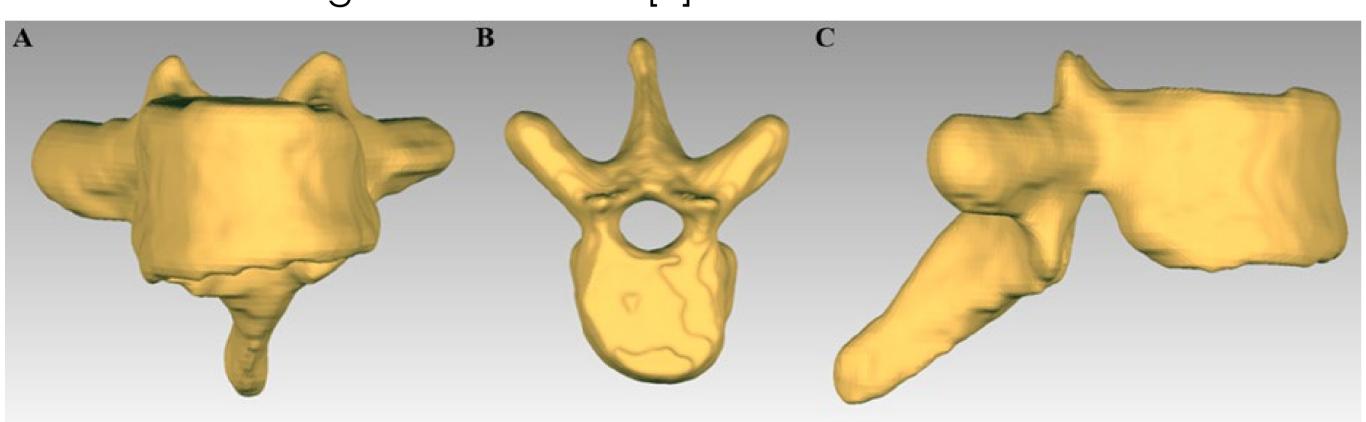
3D CT Reconstruction of a typical apical vertebrae in an AIS patient (patient age at scan = 15.2 years, Cobb angle = 58°). Typical deformities are represented in the A) coronal, B) axial (with pedicle morphology) and C) sagittal planes. Concave deformities are shown on the right side.
